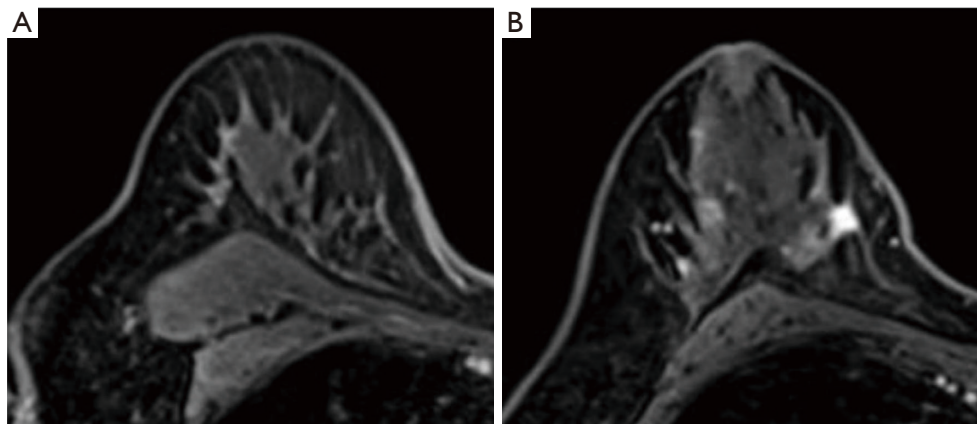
Post-treatment magnetic resonance image. The contrast effect in the right upper-outer quadrant mass disappeared (A). The tumor in the lower inner area of the right breast is the same as before treatment (B).
